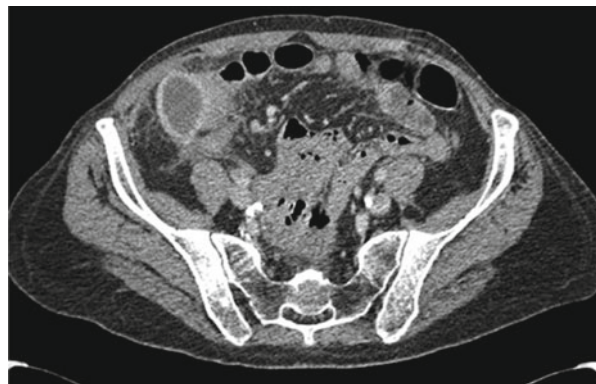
(a) CT scan showing an abscess around cecum. (b) CT scan, percutaneous drainage abscess
